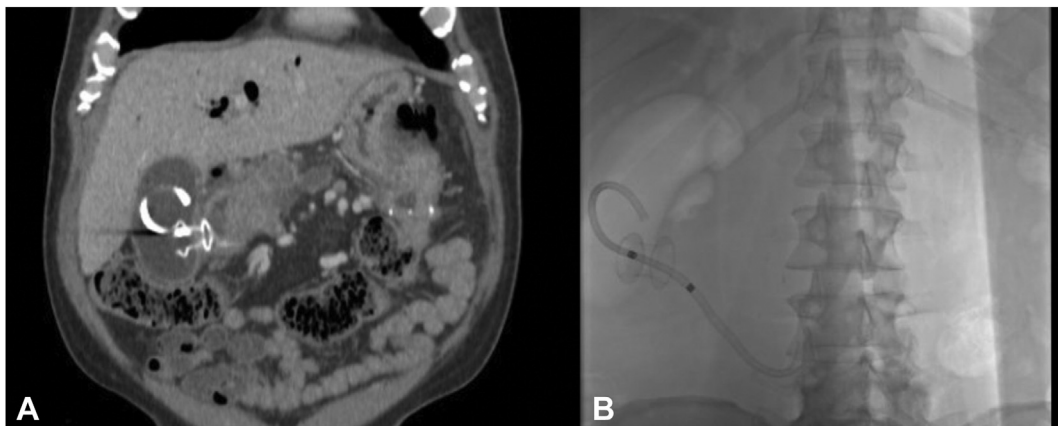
CT (A) and fluoroscopic (B) images showing lumen-apposing metal stent in place after 16 months.
